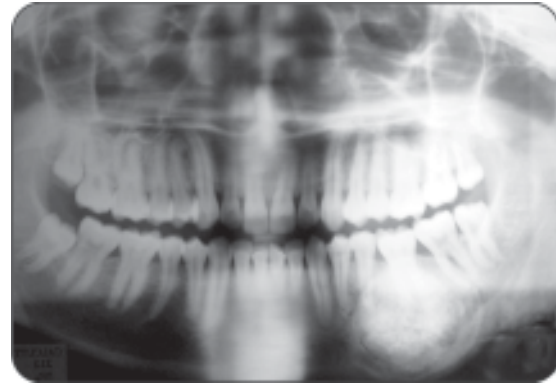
Radiograph of benign cementoblastoma
